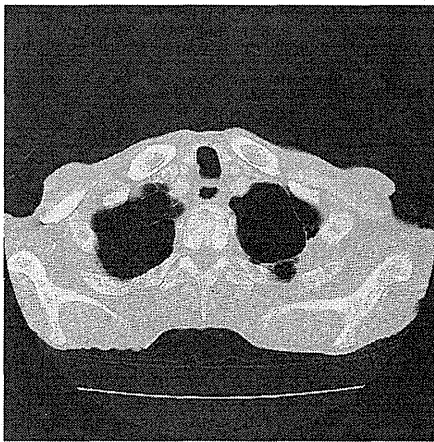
CT scan revealed the lung mass.
